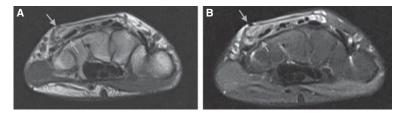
(*a*) Preoperative axial T1-weighted (*b*) and T2-weighted MR images showing heterogeneous hyperintense well-defined mass (arrows), which has similar intensity with subcutaneous fat tissue, adjacent to extensor digitorum tendon. MR: Magnetic resonance.
